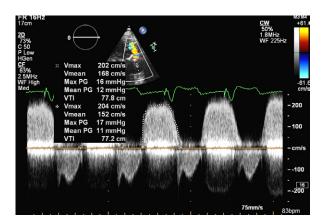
Transthoracic echocardiogram with color-flow Doppler shows prosthetic regurgitation and a mean gradient of 12 mmHg after unsuccessful valvuloplasty.
